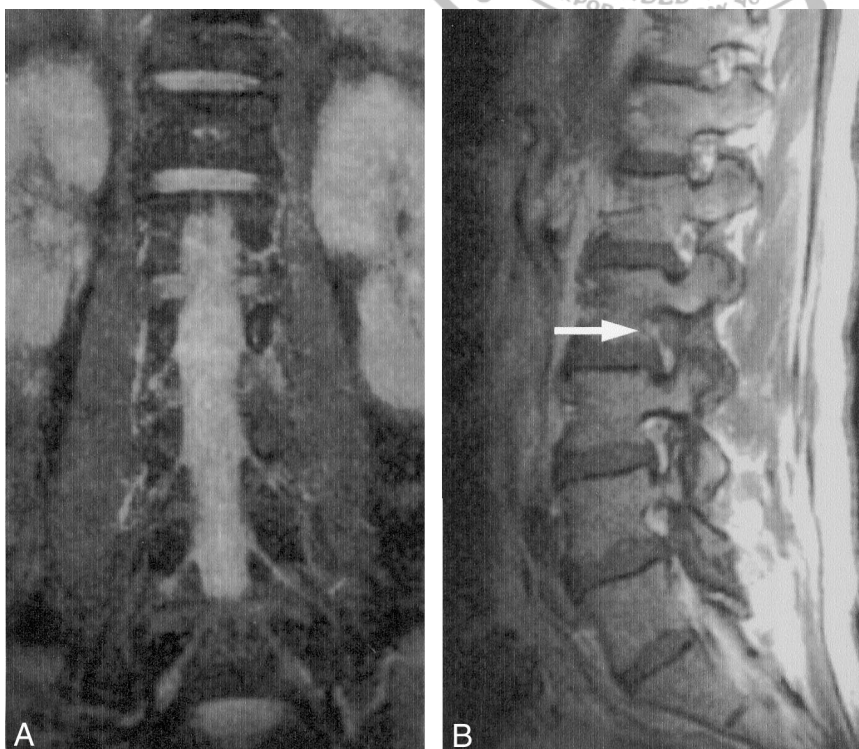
Magnetic resonance images (MRI) 7 months after epidural anesthesia. (A) T2* weighted lumbar MRI in coronal section showed disappearance of the left iliopsoas muscle swelling. (B) Note constant disappearance of fat at the left L2-L3 foramen at T1-weighted image in parasagittal section (arrow).
